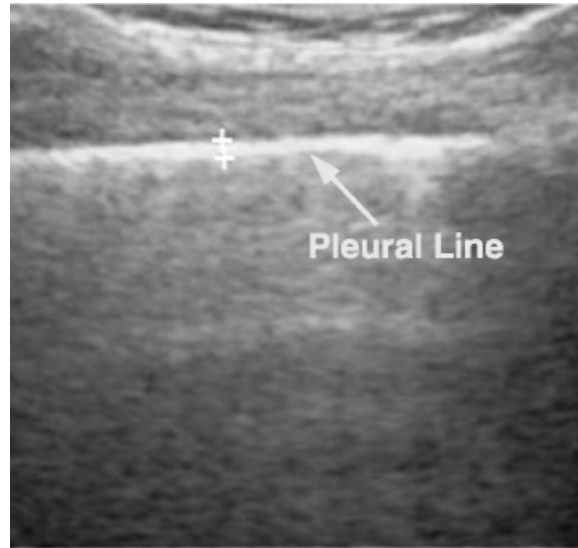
Ultrasound image showing the hyperechoic pleural line, which represents the apposition of the visceral and parietal pleura. A sliding movement in the pleural line with respirations occurs normally, and the absence of “lung sliding” is suggestive of a pneumothorax. See text for further explanation.
